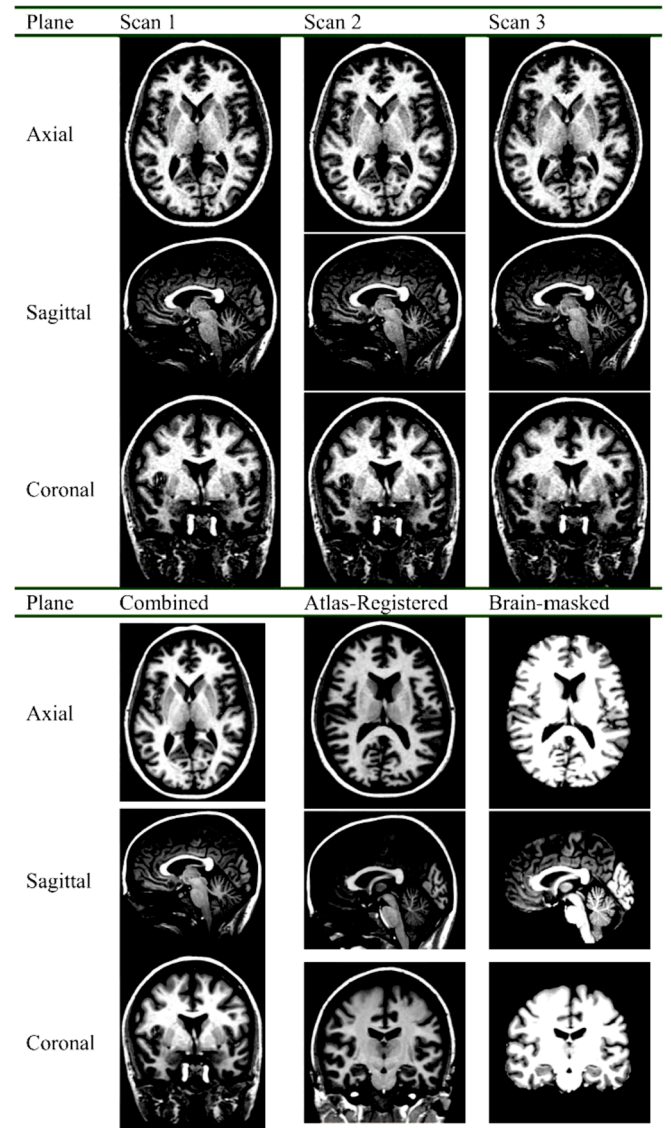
MRI preprocessing and normalization, axial, sagittal, coronal planes.
